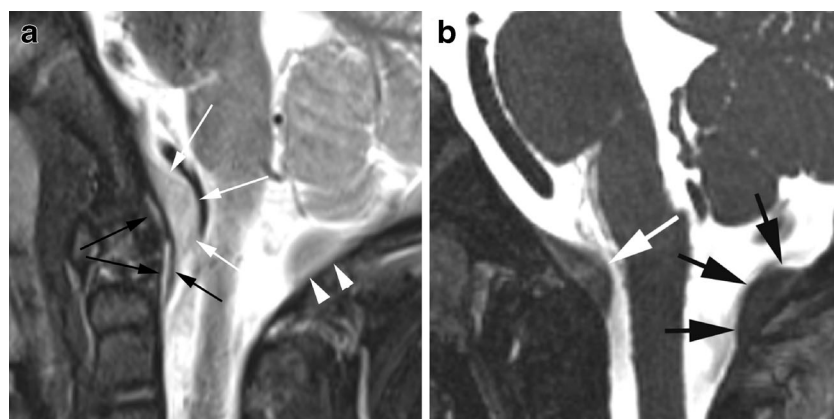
MRI in a 30-month-old girl with a combined retroclival epidural and subdural collection (case 21). a Sagittal fast spin echo inversion recovery image shows a small epidural collection (*long black arrows*) deep to the tectorial membrane (*short black arrow*). A subdural collection
